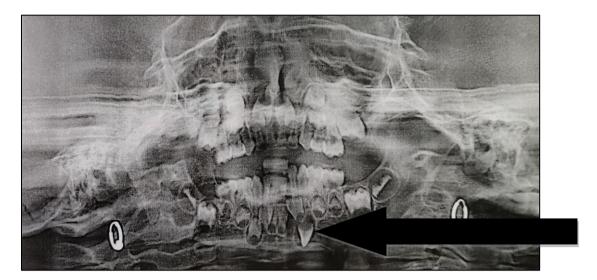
Preoperative panoramic radiograph showing fracture line and inversion of permanent tooth germ
